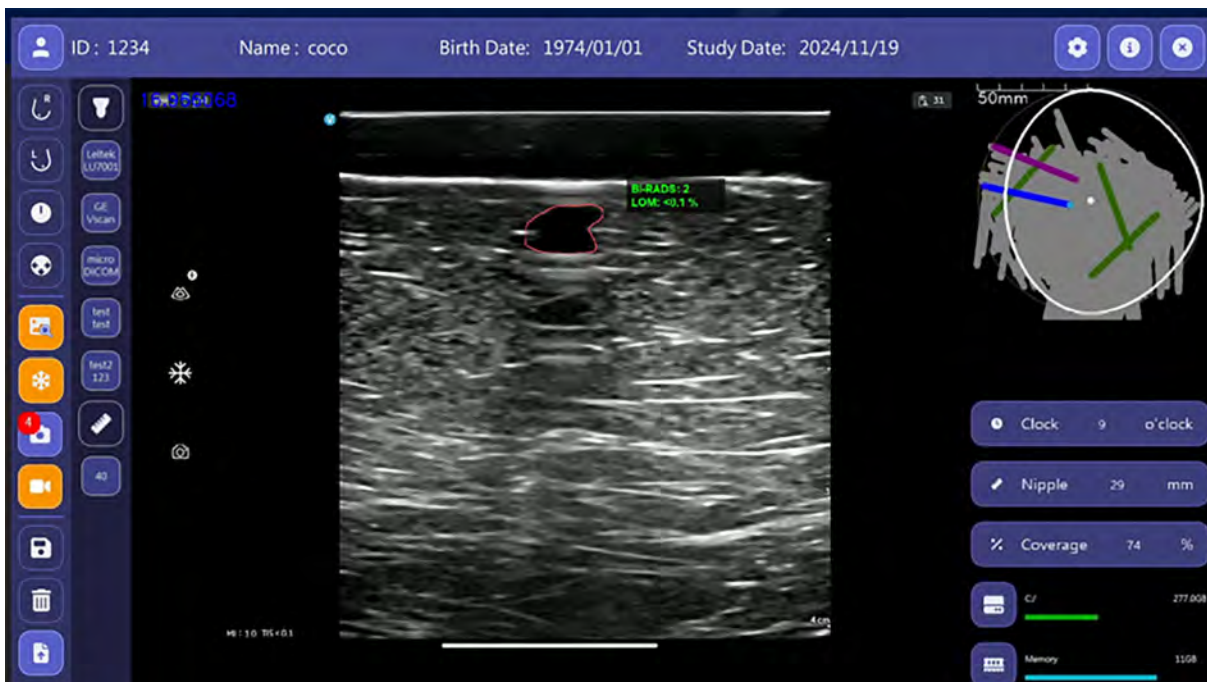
BI-RADS 2. Breast Ultrasound Computer-Aided Diagnosis interface with the US image of the outlined lesion with accompanying measurements in the center. This mass was categorized as BI-RADS 2 based on its oval shape, parallel orientation, and circumscribed margins. Image courtesy of TaiHao Medical Inc.
